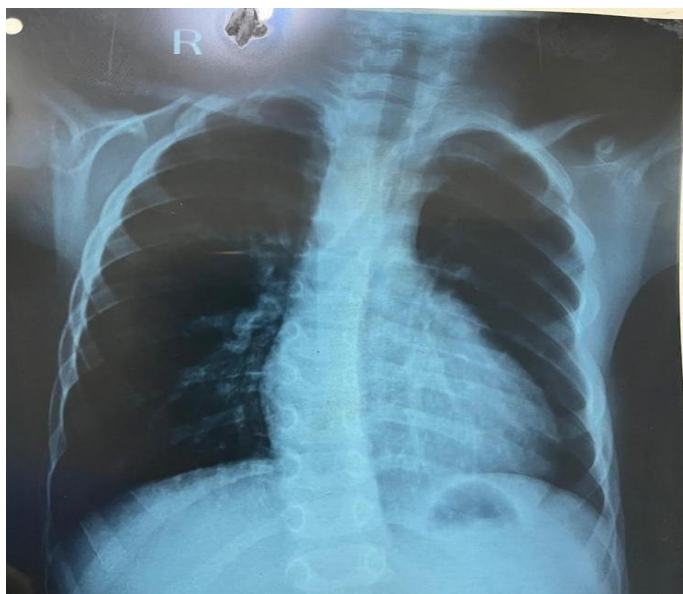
Chest X-Ray (PA) view showing boot shaped heart with upward pointing cardiac apex due to RVH of TOF. In addition, the lung fields are oligemic due to decreased pulmonary blood flows because of significant RVOTO causing right to left shunting across the VSD. The bronchovesicular markings are reaching up to  $< 1/3$  of the lung's parenchyma. Note that this patient is also having scoliosis. TOF- tetralogy of Fallot, RVH- right ventricular hypertrophy, VSD- ventricular septal defect
